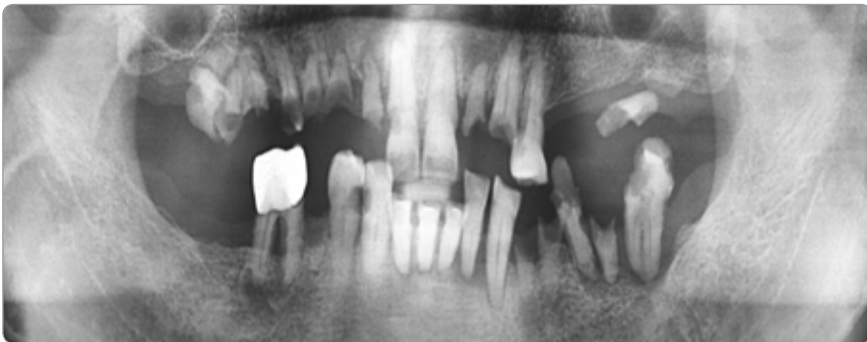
Pre-op radiography
